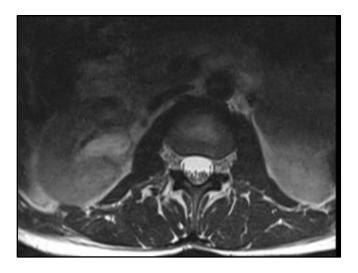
Axial view of MRI lumbar spine without contrast, T2 view in 2022.
